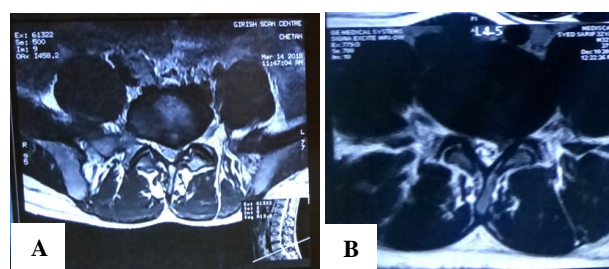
(A) MRI showing mild grade of disc prolapse; (B) moderate grade disc prolapse.
